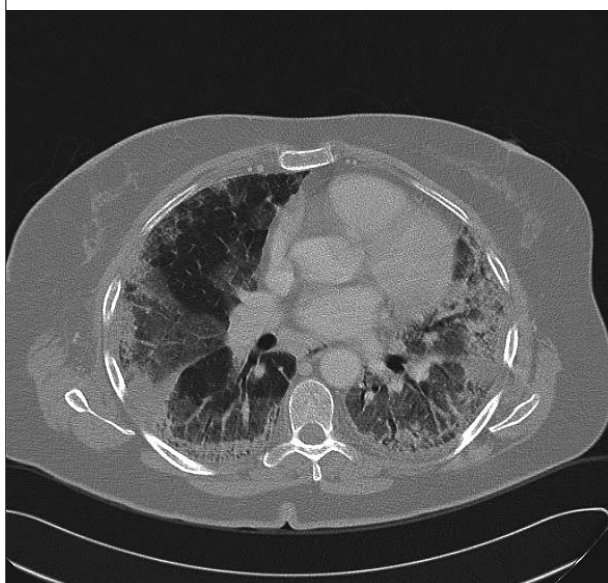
CT scan showing bilateral airspace consolidations with ground-glass opacities in patchy distribution
